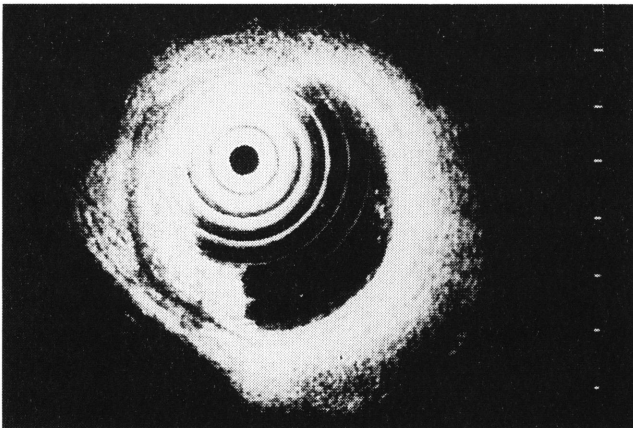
Case 3. Ultrasonic endoscopy.
